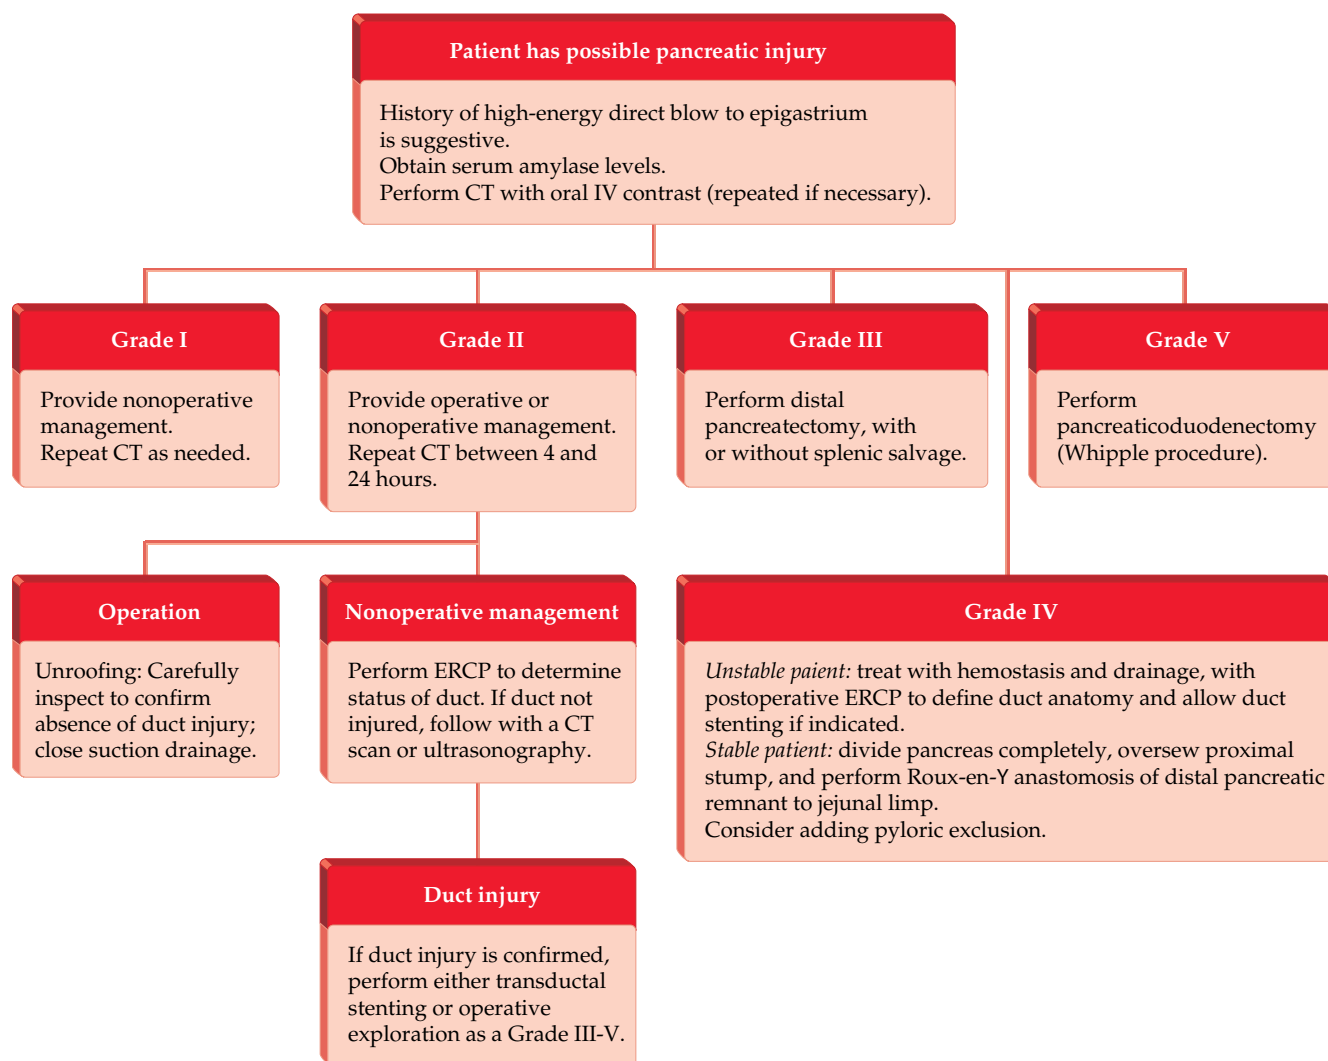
Treatment of pancreatic injury. Algorithm outlining the treatment of pancreatic injury. CT = computed tomography; ERCP = endoscopic retrograde cholangiopancreatography.
